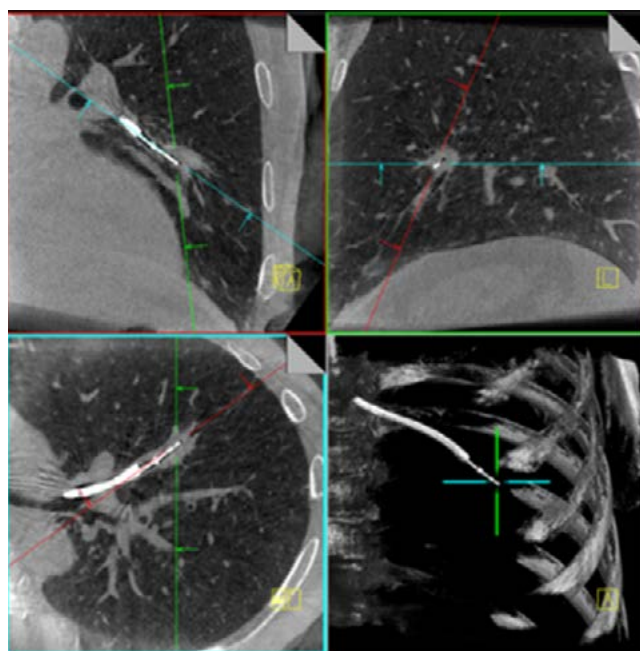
CBCT images using Cios Spin mobile system. MPR images and VRT (bottom right) from a single acquisition demonstrate lesion appearance and tool-in-lesion confirmation prior to biopsy.
